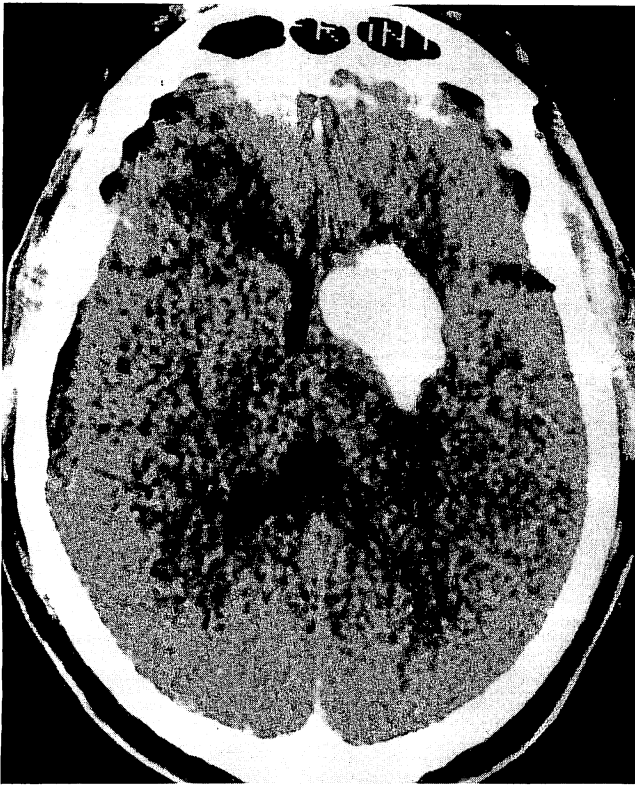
Case 2.* CT scan immediately after the intervention. High-density area, indicating the contrast medium, is located at the head of the left caudate nucleus.
